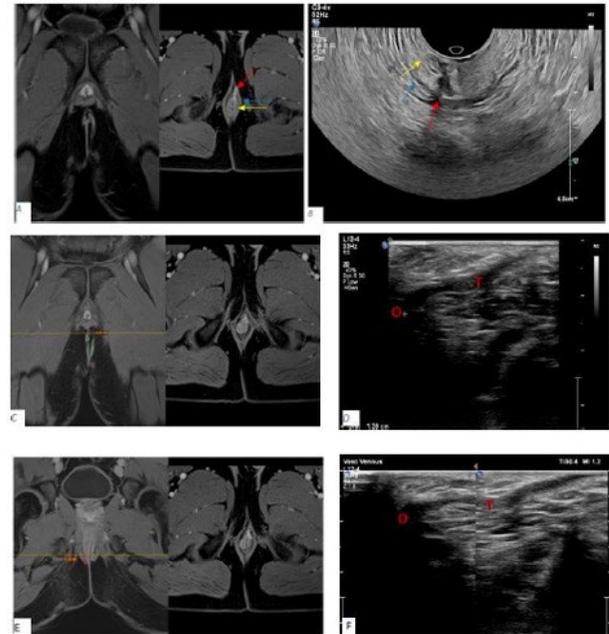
36-year old male present with perianal discharge. A) MRI fat sat T1+C coronal and axial showing transsphincteric fistula (red arrow) cross through external (blue arrow) and internal sphincter (yellow arrow). B) endocavity probe US shows transsphincteric fistula (red arrow) cross through external (blue arrow) and internal sphincter (yellow arrow). C) MRI fat sat T1+C coronal and axial, and D) liner probe US showing distance from anal verge and open to mucosa. E) MRI fat sat T1+C coronal and axial, and F) linear probe US show length of fistula tract (T: fistula tract, O: open to mucosa).
